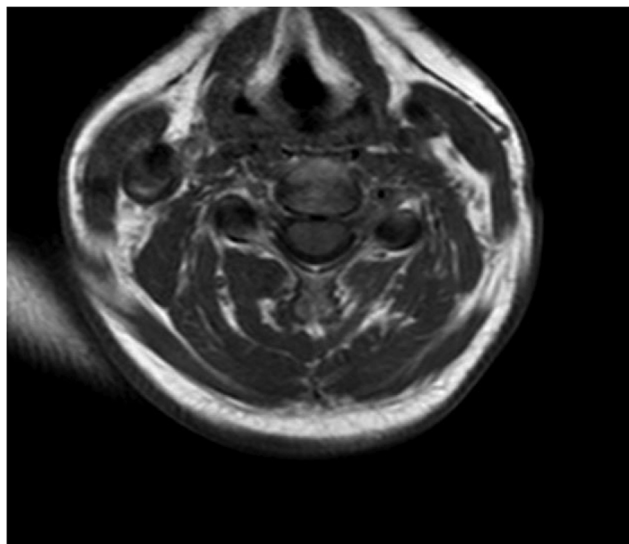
T1-weighted axial section demonstrating multifidus atrophy in the C6 plane, compatible with chronic denervation.
